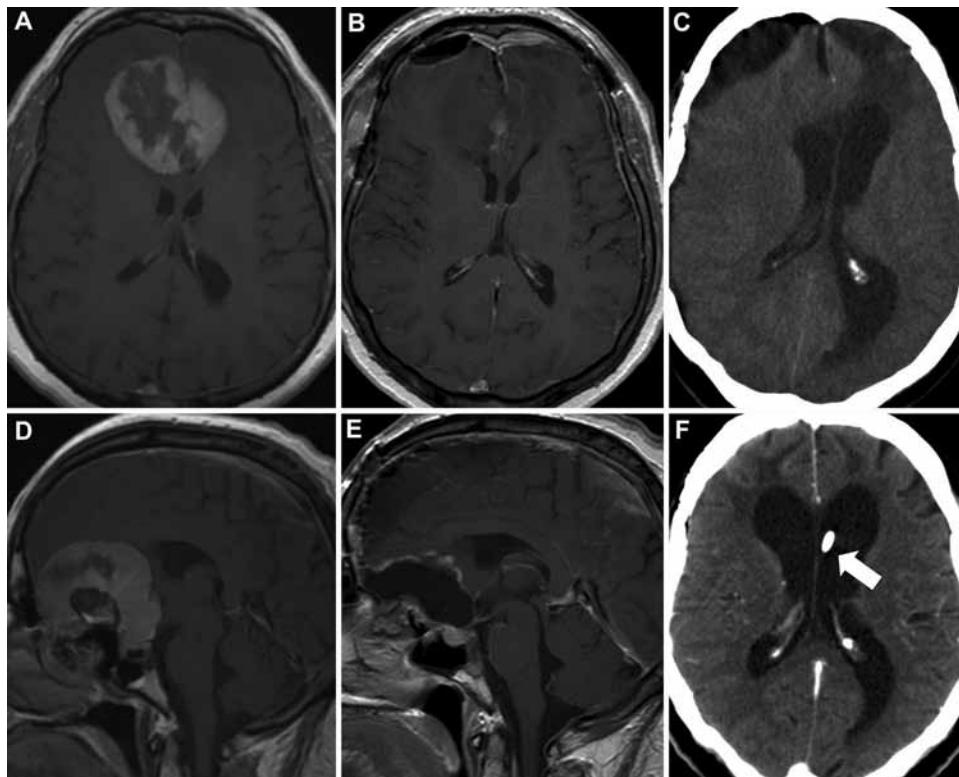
Axial and sagittal contrast-enhanced MR images obtained in a 66-year-old woman showing an extraaxial mass located in the right anterior part of the skull base (A and D). After endovascular embolization, the tumor was removed successfully via an anterior subfrontal approach (B and E), and the diagnosis of a meningioma (WHO Grade I) was made. Postoperatively, the patient showed clinical signs of hydrocephalus 10 days after surgery, and CT scans revealed radiological signs of hydrocephalus (C). On Day 14 after primary meningioma surgery, a ventriculoperitoneal shunt (arrow) was implanted (F).
